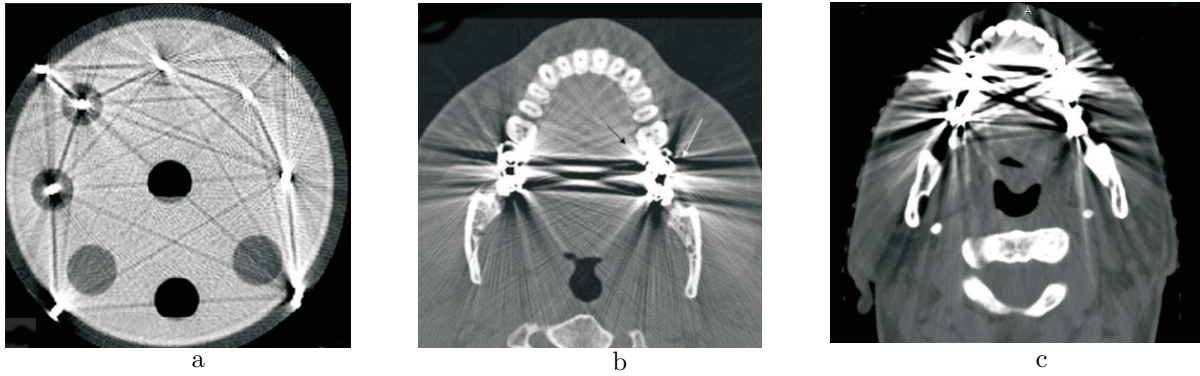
Variations of the beam hardening effect in computed tomography:
